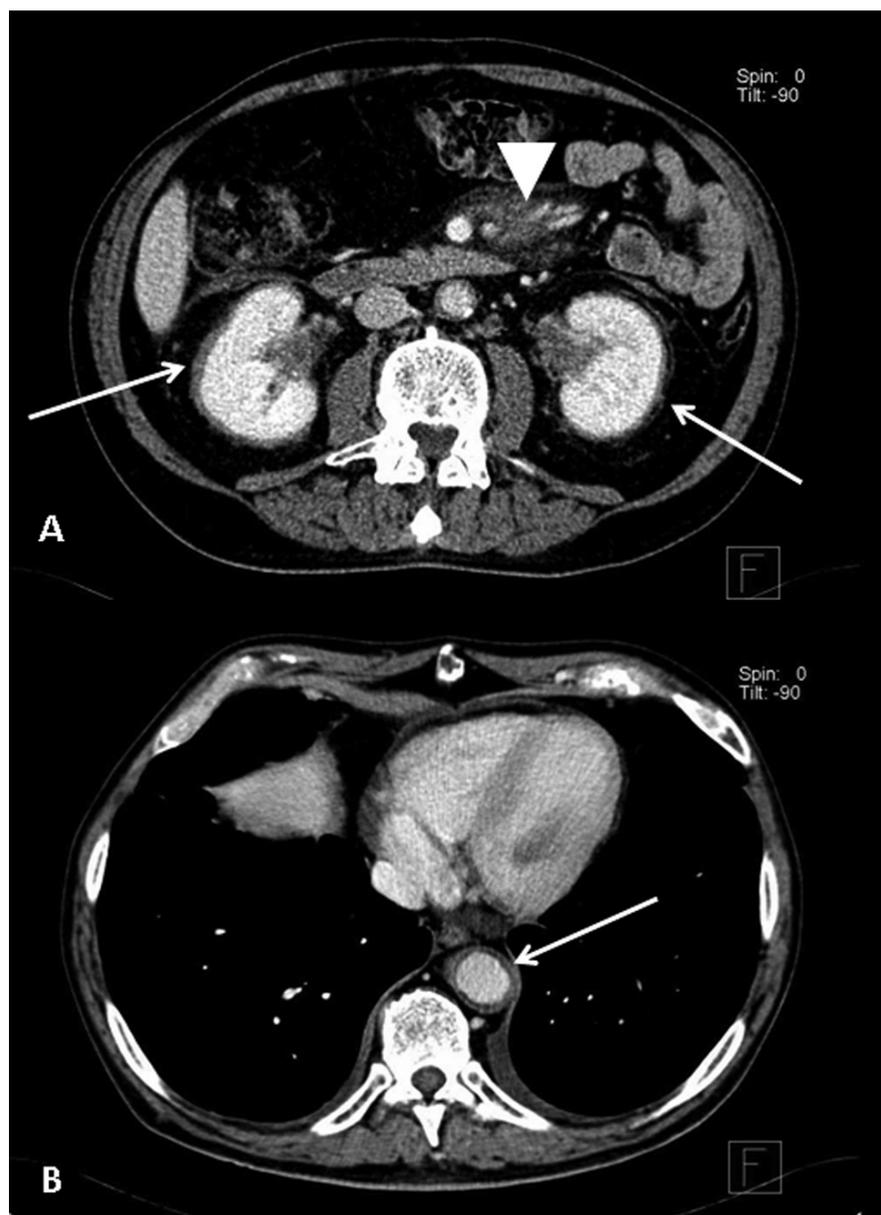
Axial thoraco-abdominal CT patterns indicative of ECD.
